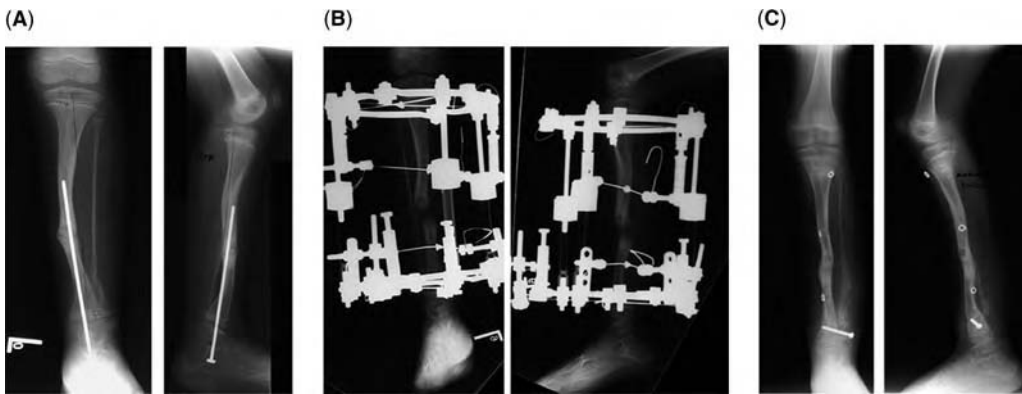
(A–C) Type III pseudarthrosis treatment. (A) Anteroposterior and lateral view radiographs of Type III pseudarthrosis with intramedullary rod previously applied and stress fracture. (B) Postoperative radiographs after application of Ilizarov external fixator for distraction of the pseudarthrosis and deformity correction. (C) Follow-up radiographs show consolidation of the pseudarthrosis and good alignment.
